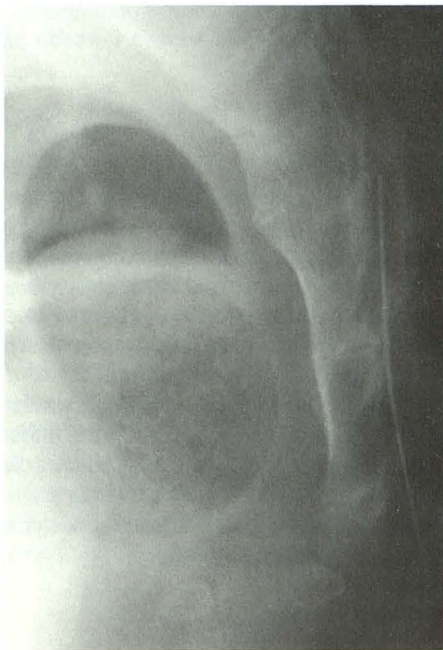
Lateral radiograph with needle appropriately positioned within sacral canal. Tip of needle is equidistant from anterior and posterior walls of the canal and lies at S3–S4 interspace.
